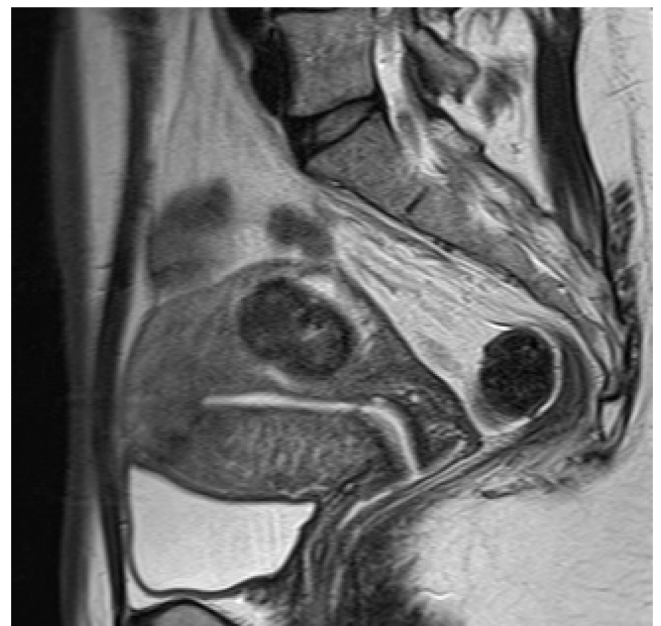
MRI image of the one month after operation.
